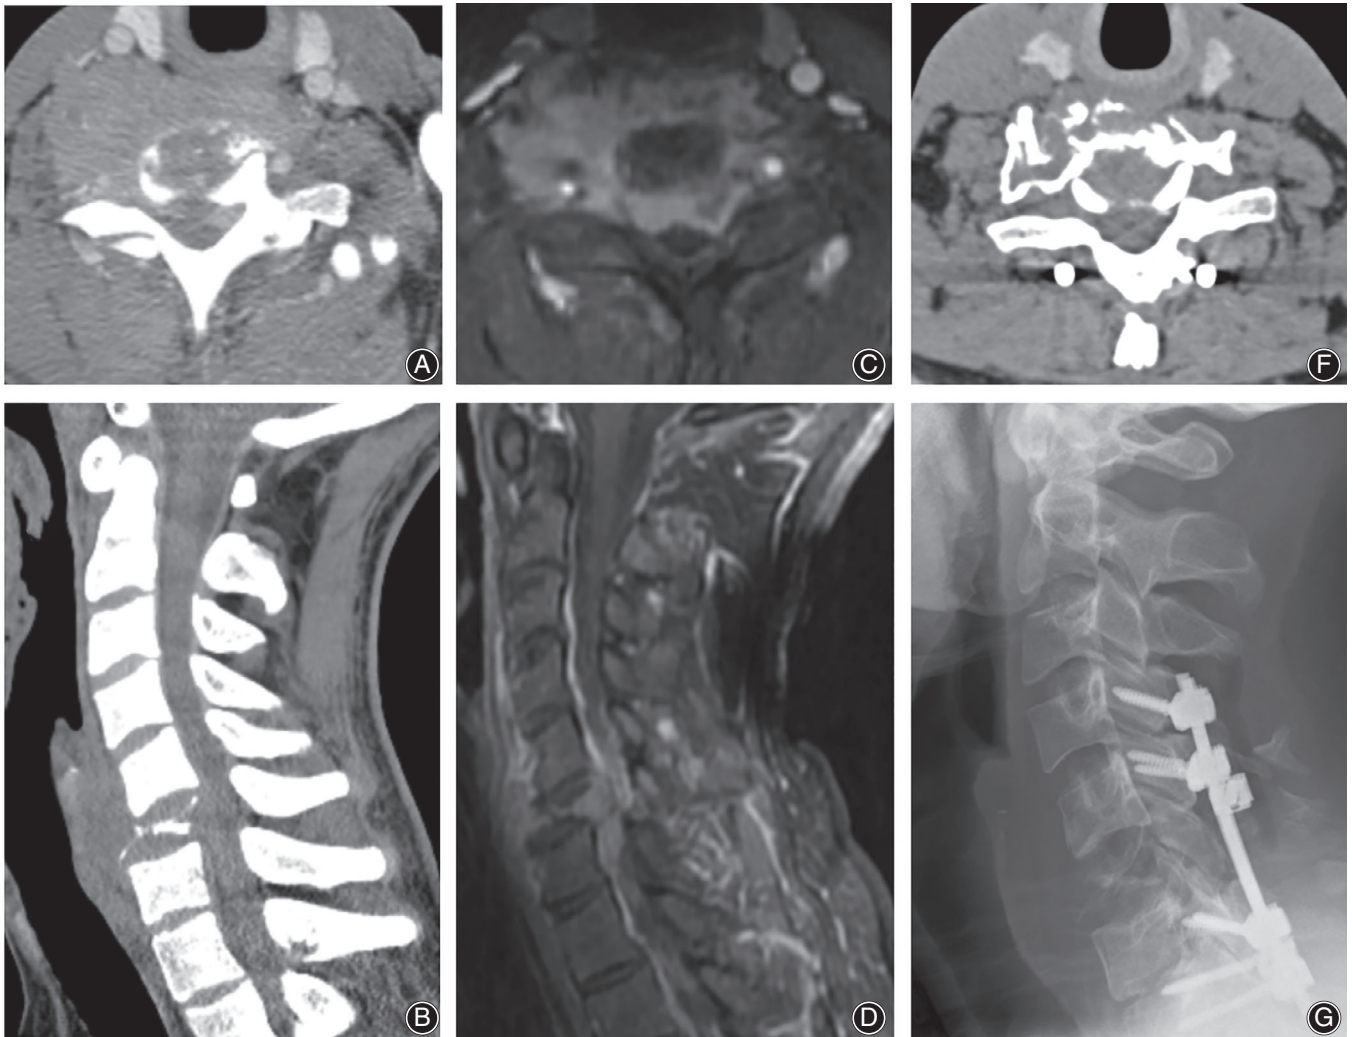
A 24-year-old man, (A, B) sagittal and axial CT images showed destruction area of C6 vertebra with obvious vertebral compression. (C, D) MRI images showed the lesion with extension into the spinal canal is mainly located in the vertebral body. (E, F) The patient managed with intralesional spondylectomy by post-access surgery. Bilateral lamina and right side attachment were removed and internally fixed, during the 5-year follow-up period, there was no evidence of recurrence, and now the patient is still on visit.
